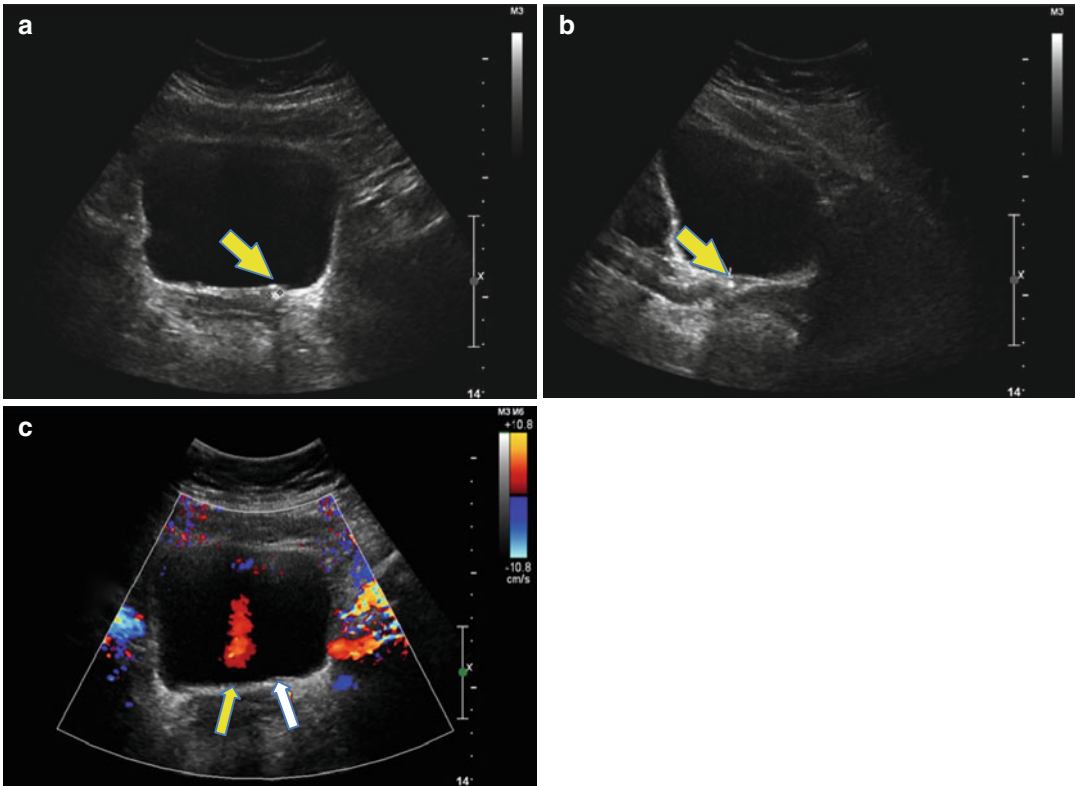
Urinary bladder ultrasound image demonstrating left UVJ stone (*yellow arrow*) in the (a) transverse and (b) longitudinal view. (c) Ureteral jet (urine flow)
